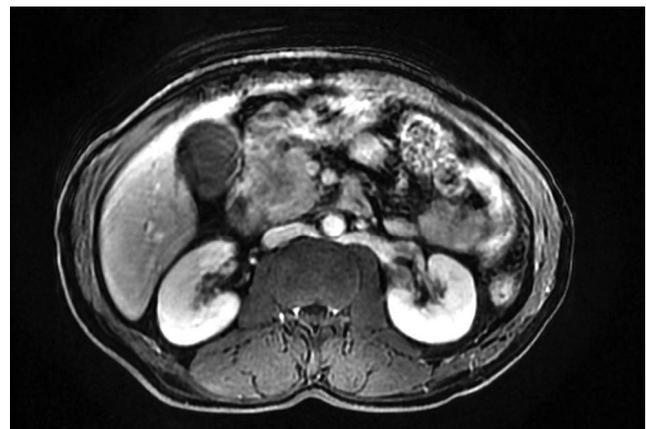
Axial plane MRI showing the retroaortic position of the left renal vein
